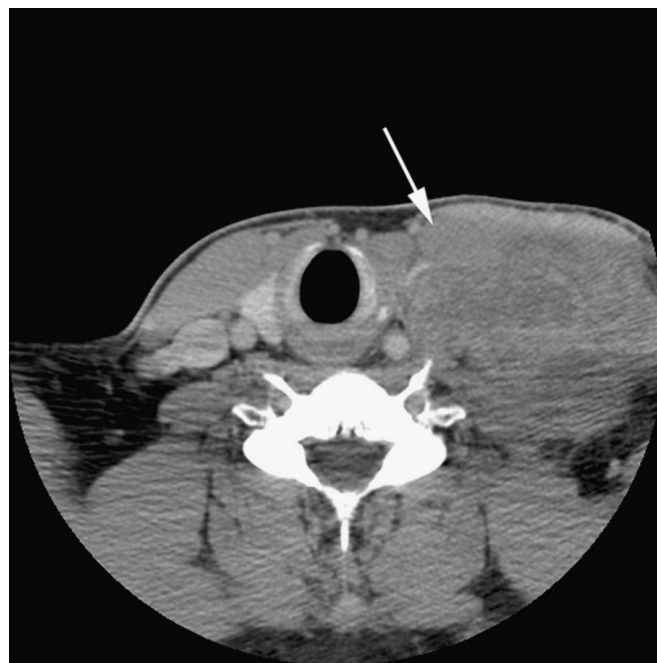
Metastatic involvement by melanoma. Axial contrast-enhanced CT image demonstrating a large tumor between the anterior (arrow) and obliterated middle scalene muscles, likely affecting the brachial plexus trunks.
